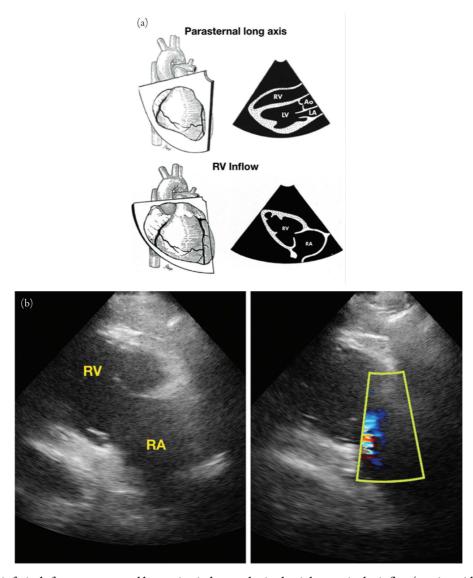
(a) Tilting inferiorly from a parasternal long axis window to obtain the right ventricular inflow (or tricuspid tilt) window. Adapted from Figures 4 and 5 of Ho SY, Nihoyannopoulos P. Anatomy, echocardiography, and normal right ventricular dimensions. *Heart*. 2006, 92(Suppl I):i2–i13. (b) Right ventricular inflow views. The image on the left is a 2D image while the image on the right shows tricuspid regurgitation on color Doppler.
